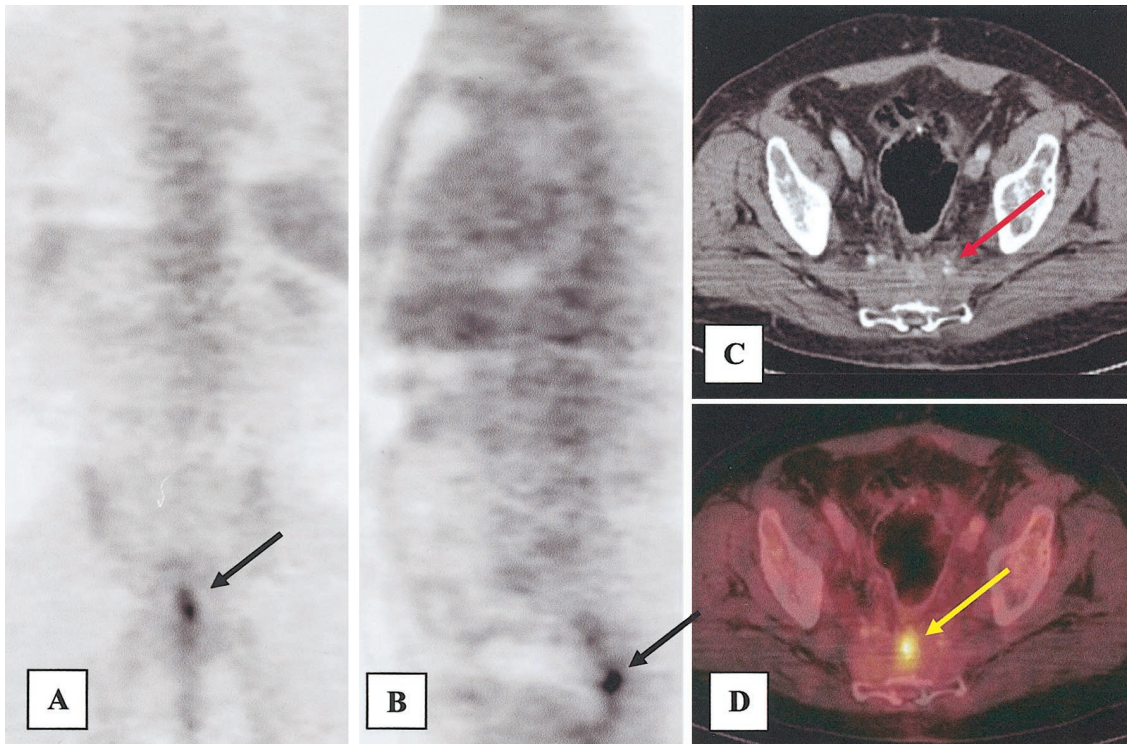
(A) Coronal PET. (B) Sagittal PET. (C) Axial CT. (D) Axial PET/CT. Patient with a history of colorectal cancer had undergone sigmoid resection and then presented with rising CEA levels. PET images demonstrate intense uptake in the presacral space that appears to correspond to the large presacral mass seen on the CT scan (red arrow). PET/CT image shows clearly that only a small part of the large presacral mass was involved. These fused images led to a directed biopsy of this area, which confirmed recurrent adenocarcinoma.
